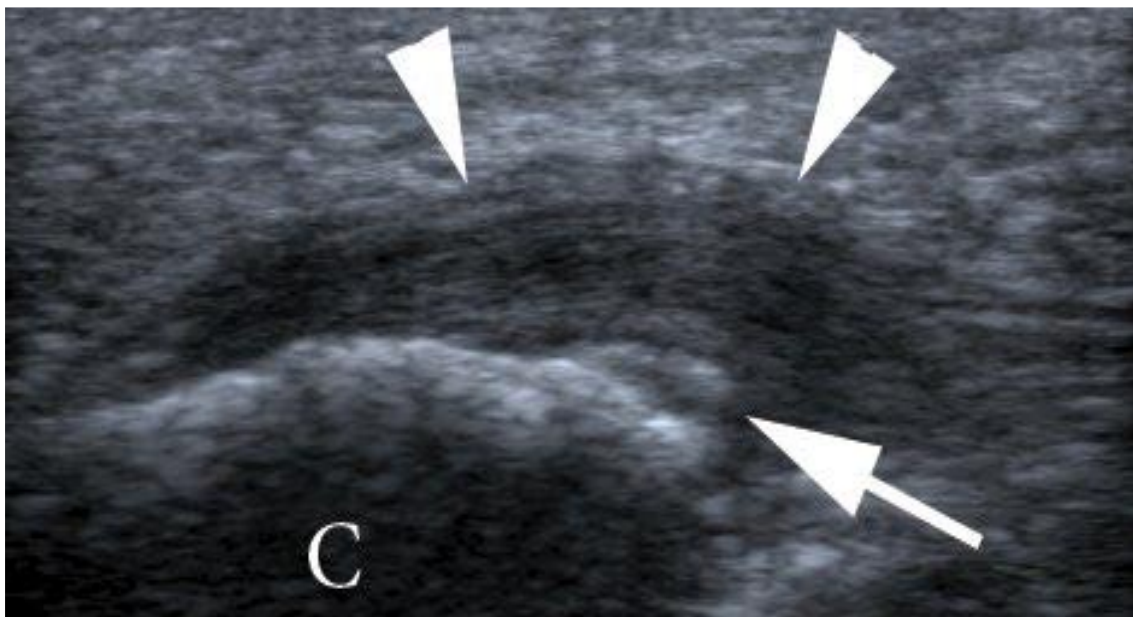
Plantar fasciitis on US with a bony spur at the insertion. Image adapted from a study by Claire Filippini, 2019 on Ultrasound features of the sole of foot pathology (14)
